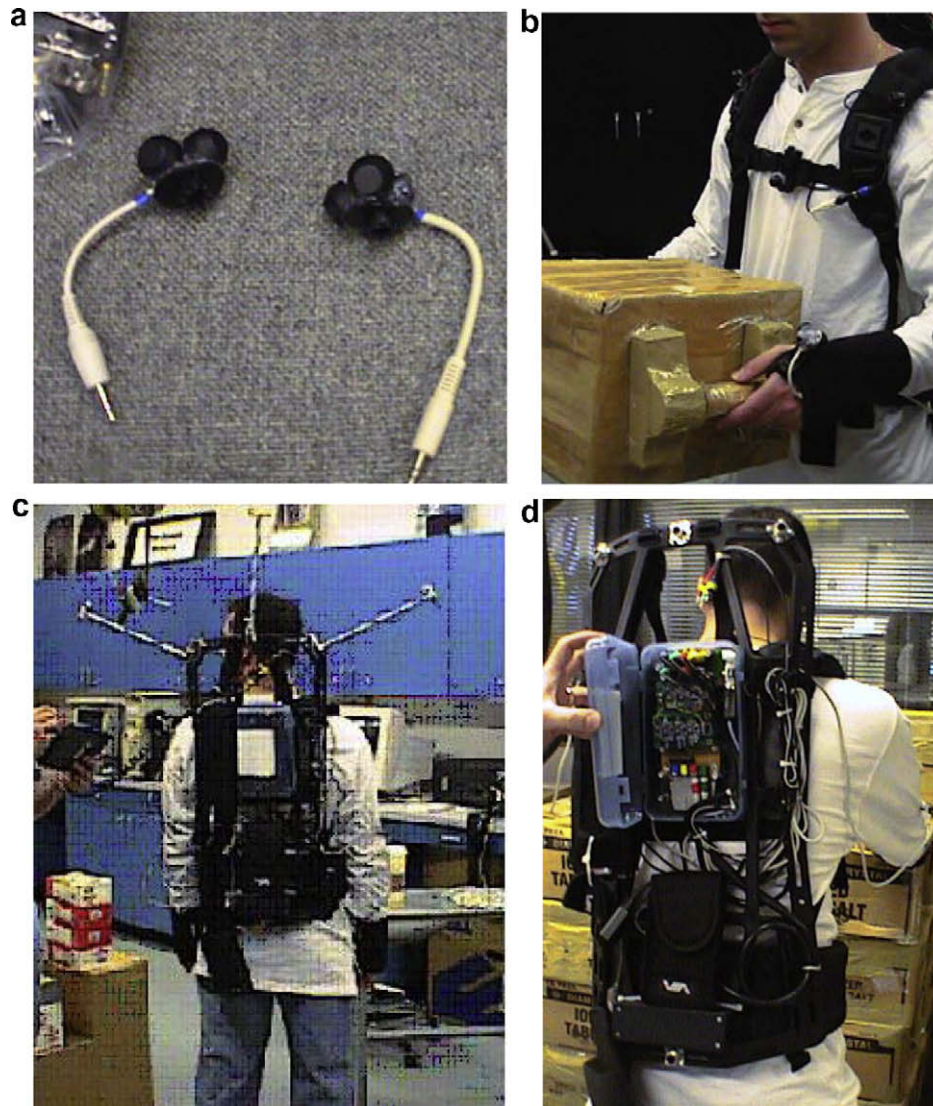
Sonic (ultrasound) receiver cluster (a), sonic transmitters mounted on the subject's hands and receivers visible on the backpack belts (b), backpack hardware system with receivers protruding from the backpack frame (c), and a close up view system electronics including the DAQ board, accelerometer (black box at base of backpack), and wearable computer (black pouch) (d). The prototype system weighed nearly 17 kg.
